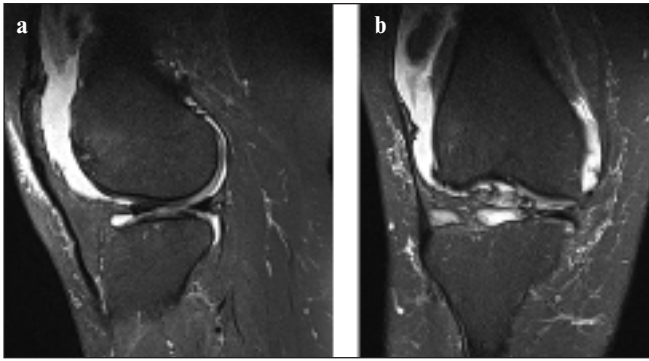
Magnetic resonance imaging of the knee (a, b)
